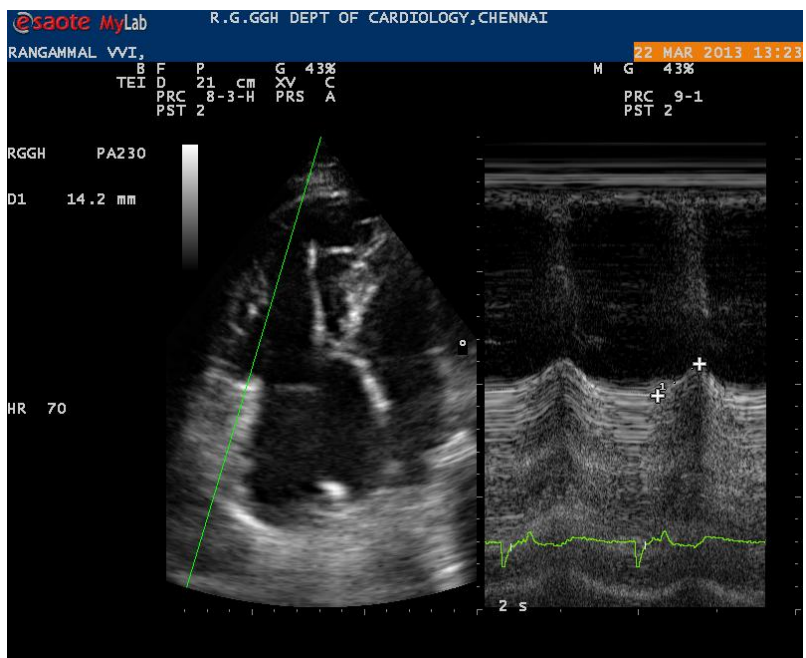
B showing Apical 4-chamber view for measuring TAPSE. The M-mode cursor placed along the lateral annulus of the tricuspid valve
